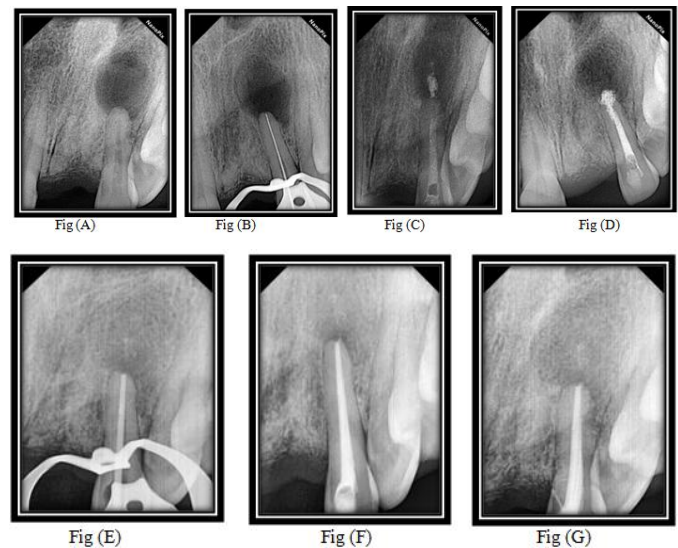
Showing a step-by-step procedure of cyst treatment. A) Pre-operative Radiograph B) Working length Determination C) CA (OH) 2 Dressing given for 7 days. D) Metapex Dressing E) Master Cone selection F) Post operative G) complete healing of periapical bony lesion after 3 month follows up.
